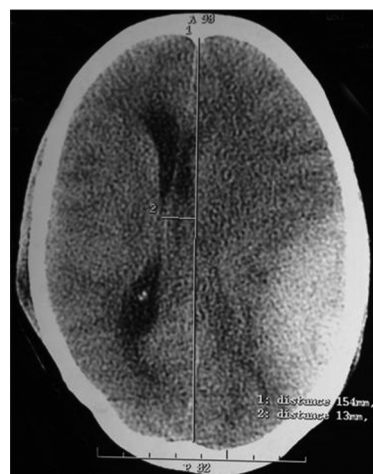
Axial CT scan of brain showing, EDH over LT parietal area with mass effect and diffuse brain oedema
